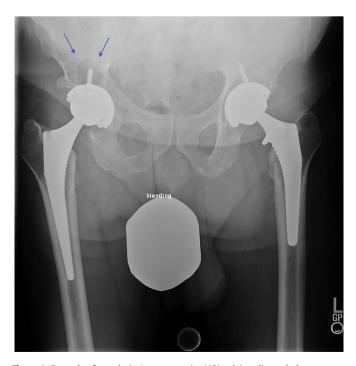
Example of osteolysis. Anteroposterior (AP) pelvis radiograph demonstrates bilateral total hip arthroplasty. The left hip appears well fixed. The right hip contains the Exactech Connexion GXL liner. There is extensive osteolysis of the supra-acetabular region with asymmetric polyethylene wear, as indicated by the arrows.
